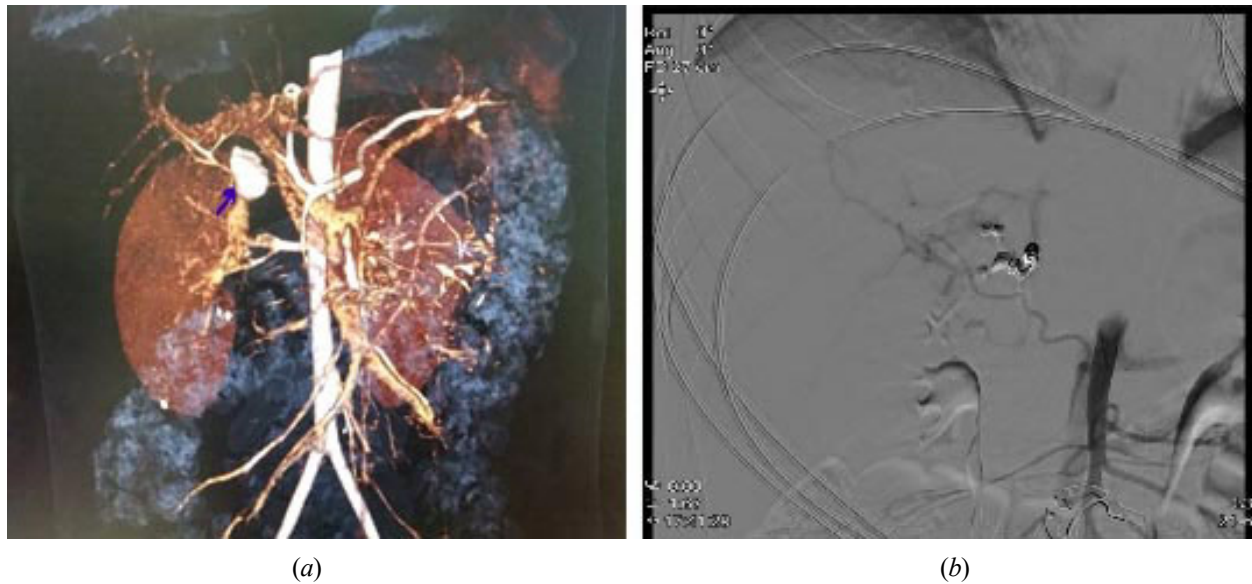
(a) Pseudoaneurysm of right hepatic artery in CT-angiography (arrow), (b) Coil embolization of the pseudoaneurysm of right hepatic artery.
